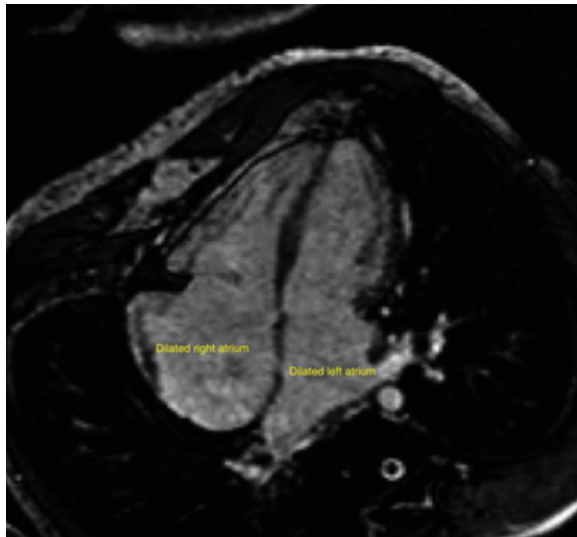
Restrictive cardiomyopathy. Four-chamber magnetic resonance imaging showing markedly dilated atria with normal ventricular sizes. The systolic function is usually normal, but diastolic relaxation is severely impaired resulting in restrictive filling of both ventricles. Courtesy of Michael Taylor, MD
